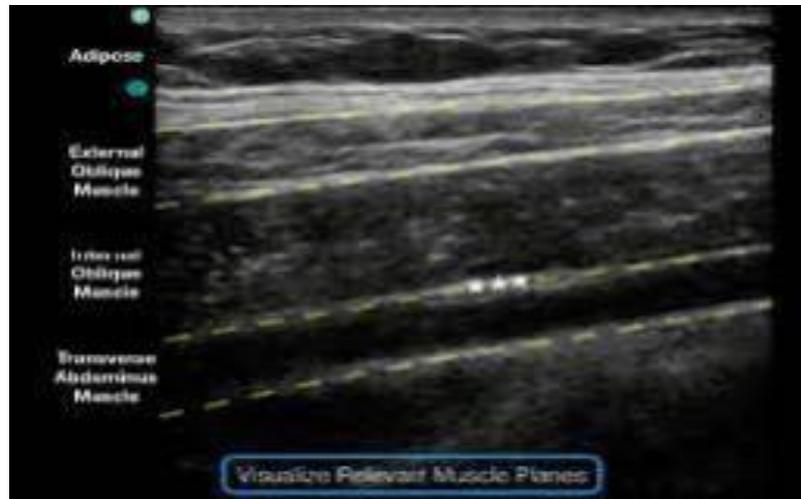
Ultrasonogram of transversus abdominis muscle and block location
